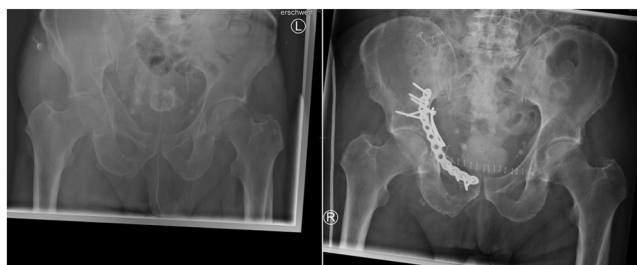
Simple acetabular fracture of the anterior column on the right side pre- and post-operative. For stabilization, a suprapectineal plate fixation (Fa. Stryker) was used: 69 years old male patient suffering from an acetabular fracture caused by falling from a bicycle. In the X-ray, one can see a fracture of the anterior column. In the additional CT scans, there is further affection of the quadrilateral surface without major dislocations. Intraoperatively, suprapectineal plate fixation with a plate by Stryker was chosen. Postoperatively, the patient could be mobilized on crutches under 20% partial weight-bearing.
